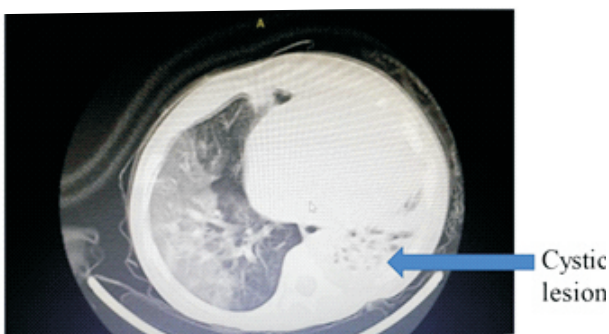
Chest CT showing multiple cysts with hyperlucency of the left lung in the toddler
